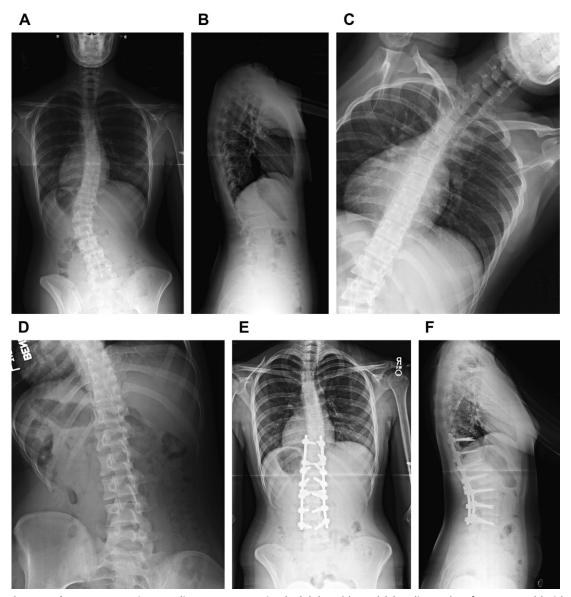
Lenke 5. Preoperative standing posteroanterior (PA) (A) and lateral (B) radiographs of a 17-year-old girl with a left 45° main lumbar curve and a right 28° thoracic curve. Right (C) and left (D) bend films show that the main lumbar curve bends down to 7° and the thoracic curve bends down to 14°. One-year follow-up PA (E) and lateral (F) radiographs show correction of the main lumbar curve to 10° and correction of the thoracic curve to 6° with posterior pedicle screws from T10 to L4.
